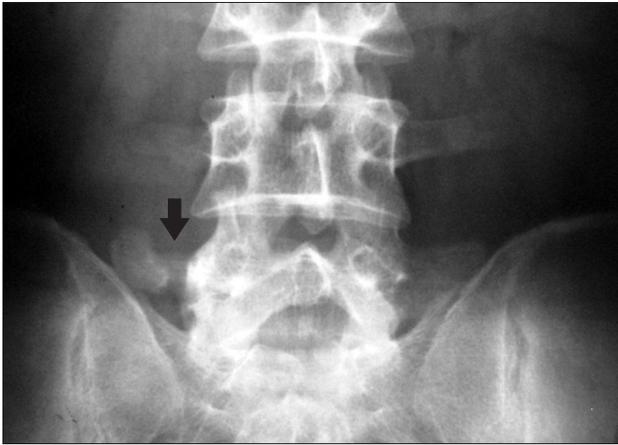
The plain radiograph shows a subtle osteolytic lesion with surrounding sclerosis of the right transverse process of L5 (arrow).
